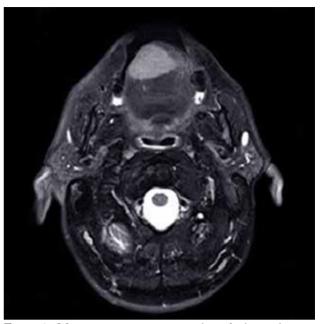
Magnetic resonance imaging showed a lesion that was homogeneous on contrast enhancement.
